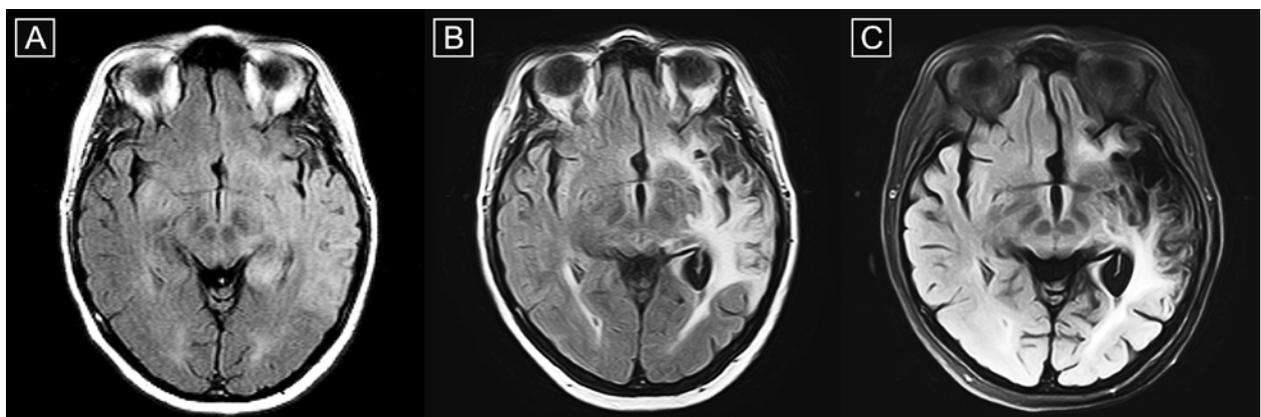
a-c. Progressive left temporal lobe atrophy after HSE. Extensive, hyperintense gliosis area, hyperintense on FLAIR images, with gradual enlargement of the CSF spaces in follow-up studies (a-c; a-b: 1.5T, TR/TE=8000/120; c:3T: FLAIR Fatsat TR/TE 8000/96).
